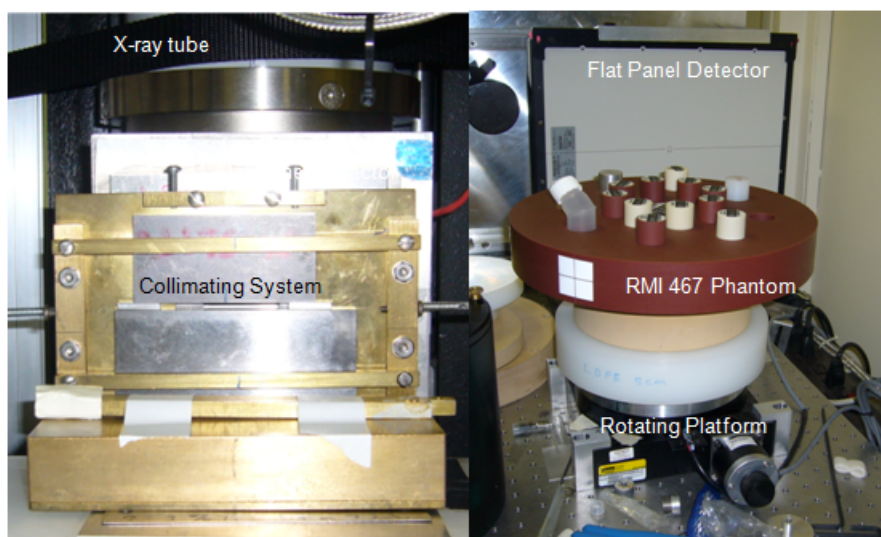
Experimental setup of the bench-top CT imaging system.
